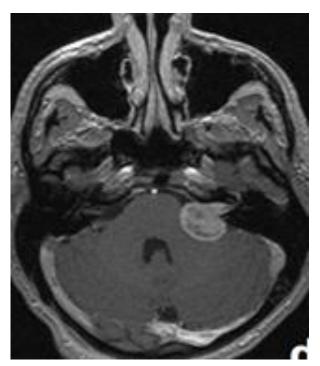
MRI in T1-weighted mode of patient V. 53 years old.
